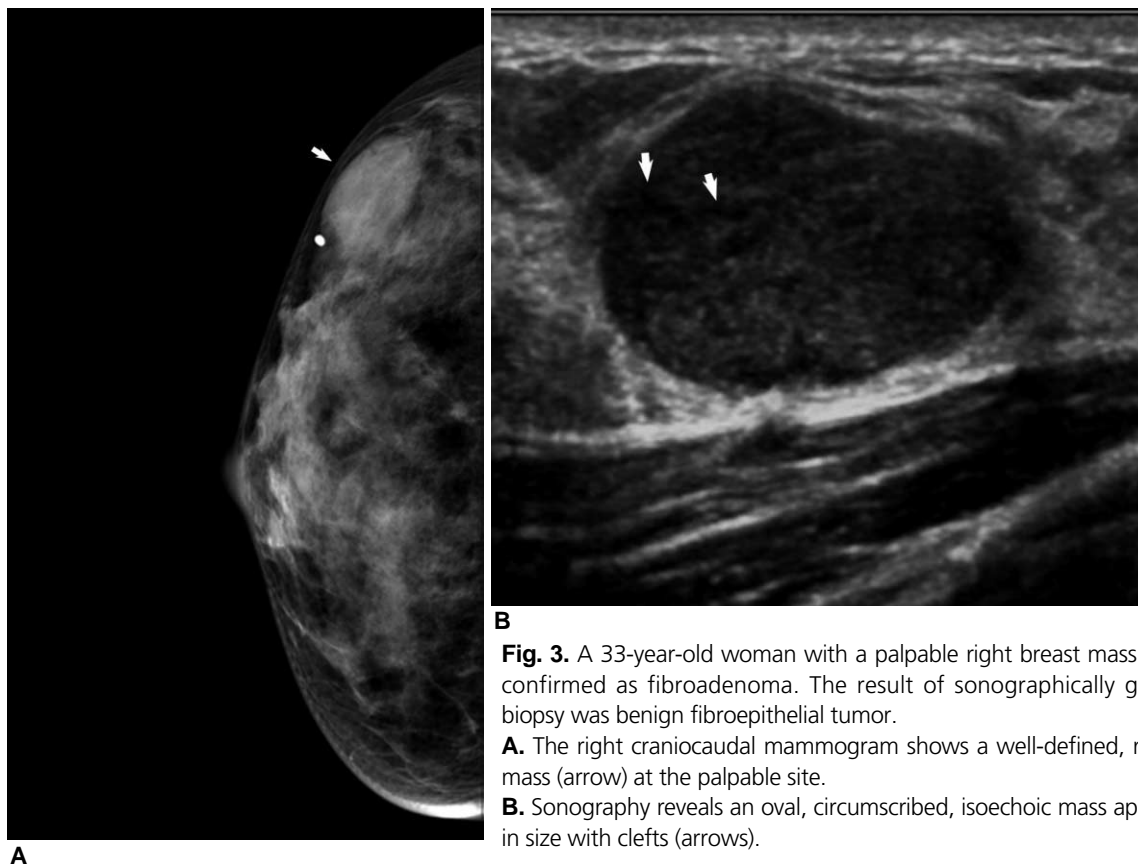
A 33-year-old woman with a palpable right breast mass that was surgically confirmed as fibroadenoma. The result of sonographically guided core needle biopsy was benign fibroepithelial tumor.
